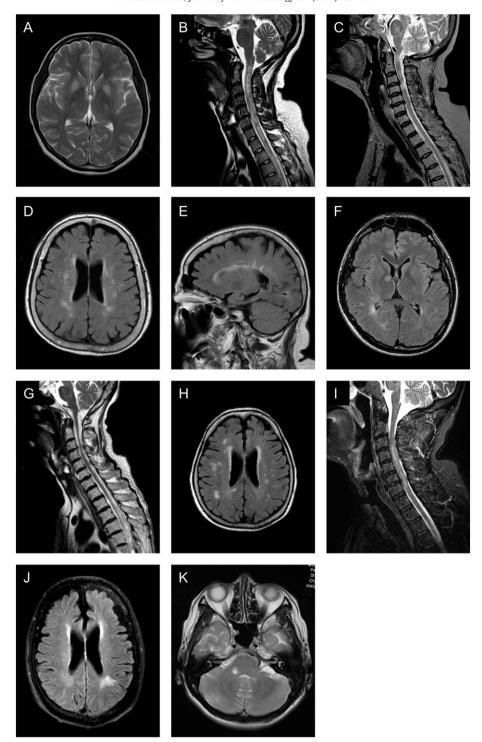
CNS lesions of some patients with CNS demyelinating disorder. (A and B) MRI images from a 34-year-old woman who was AQP4-seropositive NMO with anti-NMDAR Abs. (A) T2-weighted brain MRI showing bilateral putamina lesions. (B) T2-weighted cervical cord MRI showing multiple long lesions. (C-E) MRI images from a 69-year-old woman who was AQP4-seropositive NMO with anti-NMDAR Ab. (C) T2-weighted cervical cord MRI showing multiple lesions. (D and E) Brain MRI (fluid-attenuated inversion recovery, FLAIR; axial and sagittal) showing multiple periventricular and corpus callosum lesions characteristic of MS. (F) Brain MRI image (FLAIR) from a 39-year-old MS patient with anti-NMDAR Ab showing a few periventricular lesions. (G and H) MRI from a 65-year-old woman who was AQP4-seropositive NMO with anti-CASPR2 Ab. (G) T2-weighted spinal cord MRI showing a long lesion at the thoracic level with cord atrophy. (H) Brain MRI (FLAIR) showing nonspecific disseminated lesions. (I and J) MRI images from a 65-year-old man who was NMOSD with anti-CASPR2 Ab. (I) T2-weighted cervical cord MRI showing LESCL in C3-C7. (J) Brain MRI (FLAIR) showing a nonspecific periventricular lesion characteristic of leukoaraiosis. (K) T2-weighted brain MRI image from a 36-year-old woman who was CIS, showing right-sided pontine and middle cerebellar peduncle lesions.
